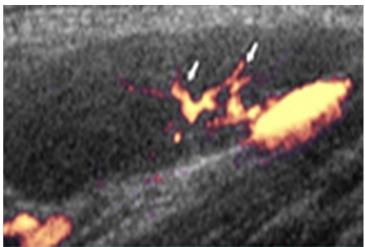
Probably malign lymphadenopathy; sections longitudinally of left armpit (with colour-coded so-called power mode sonography)
